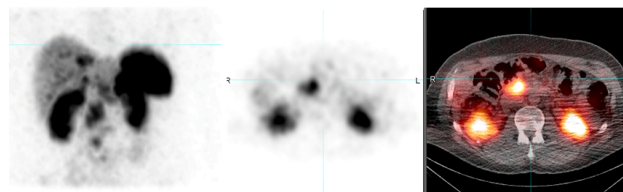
Snapshot of whole body planar, SPECT, SPECT/CT fused images acquired after first cycle of 177-Lu Dotatate therapy
